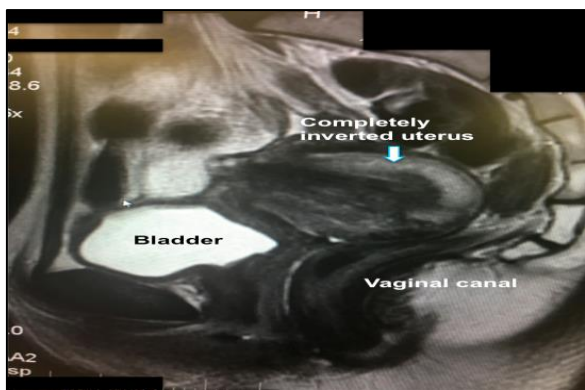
MRI of pelvis on PPD# 50 showing complete uterine inversion in the vaginal canal. Uterine endometrial lining noted to be 1.5 centimeters. Cervix was difficult to delineate and both ovaries appeared to be normal. No free fluid in the pelvis.
